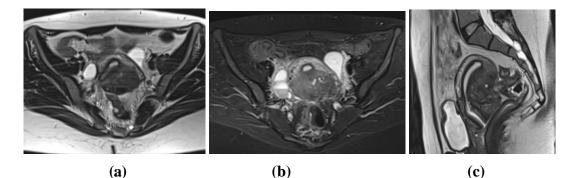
Axial T2, sagittal T2 & T1 postcontrast MRI images showing diffuse thickening of junctional zone at the posterior wall with embedded bright foci in T2WIs.the posterior wall signal alternation shows no enhancement following IV contrast administration (c) confirming the diagnosis of adenomyosis
